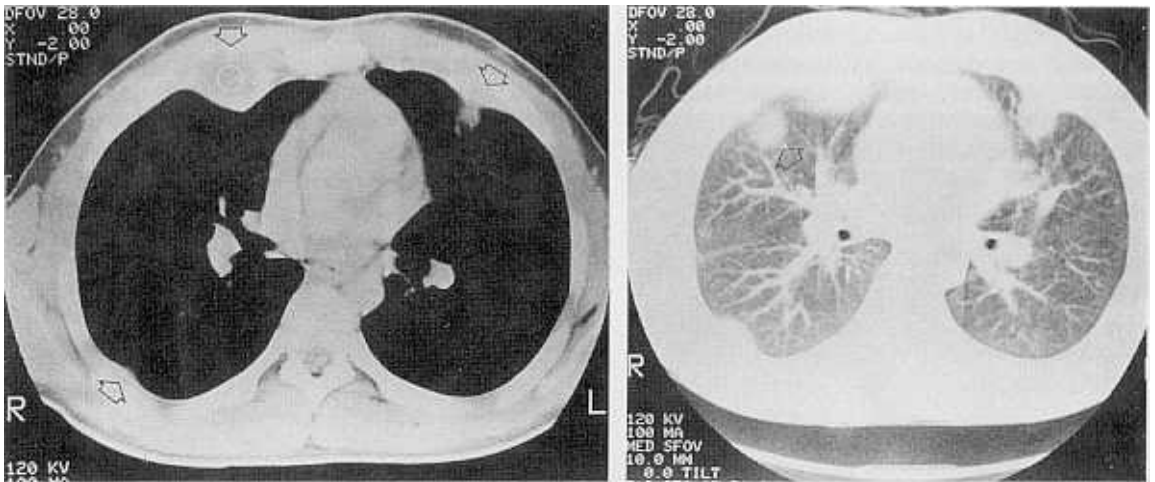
Initial CT of the chest demonstrating multiple extrapleural lesions along the both chest walls with accompanying parenchymal consolidation, predominantly subpleural in location. The lesion in the right parasternal area shows central low density, a finding consistent with caseous necrosis.
